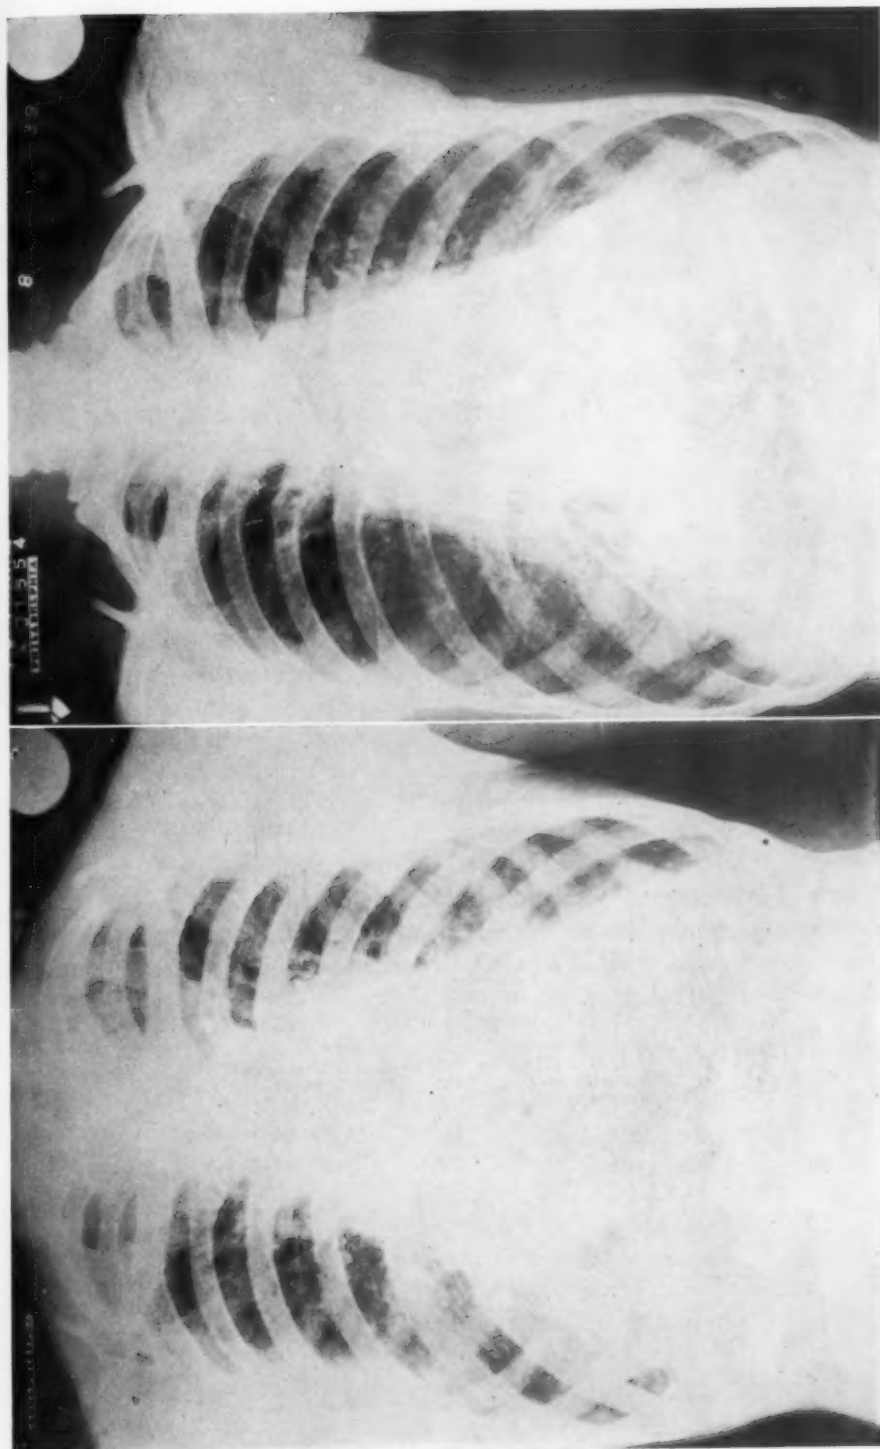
Case 2. Roentgenograms of the chest taken (A) on March 28, 1939, and (B) August 1, 1939.
